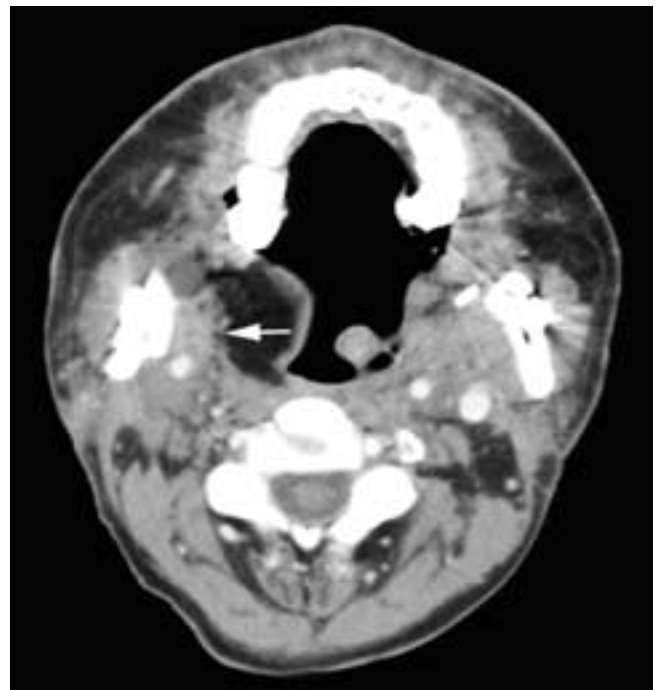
Axial contrast-enhanced CT scan (A) on a patient who has had a total laryngectomy and a left neck dissection. There is an enhancing nodule (*arrow*) of recurrent squamous cell carcinoma along the right margin of the flap. Axial contrast-enhanced CT scans (B and C) on a different patient who has had a total laryngectomy and partial pharyngectomy shows an enhancing tumor recurrence along the upper left posterior operative margin. This is a common site for recurrent squamous cell carcinoma.
